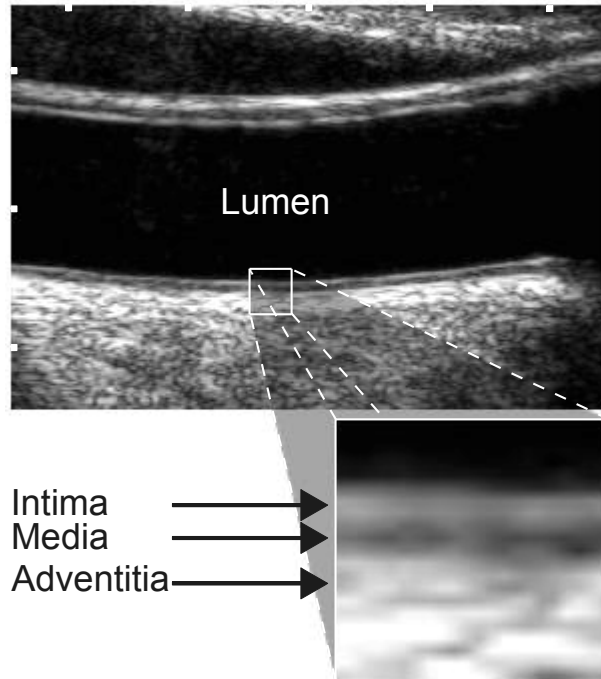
Ultrasound image of a common carotid artery. The white ticks on top and on left border of the image are placed 5 mm apart from another.
